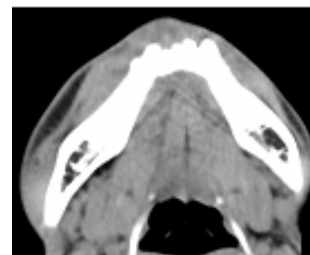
CT image shows left soft tissues and mandibular ascending are thinner than those of right side
